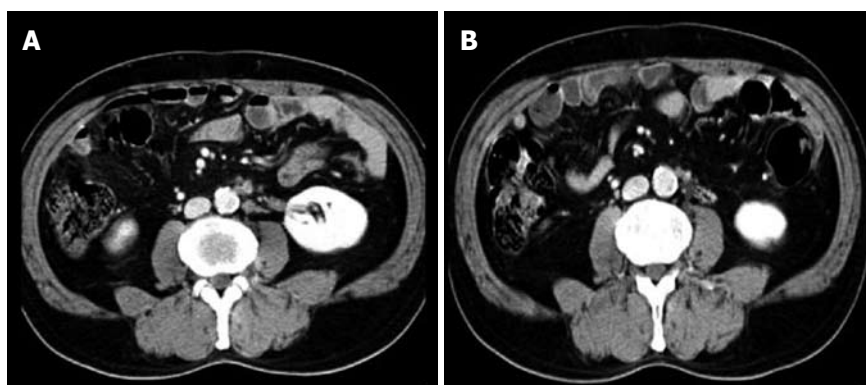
Computed tomography (CT) images obtained in a patient with paraaortic lymph node recurrence before (A) and 2 mo after (B) stereotactic body radiotherapy (SBRT).
